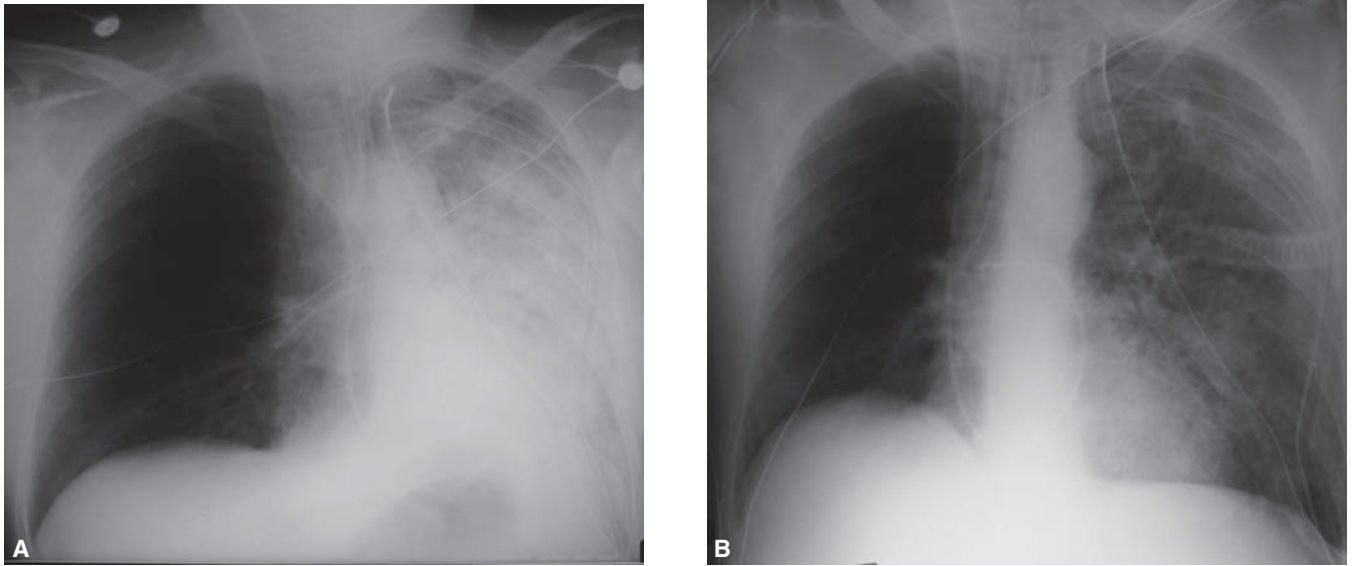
Chest X-rays of a patient with a right single-lung transplant before (A) and (B) after insertion of a right double-lumen tube and independent lung ventilation.
